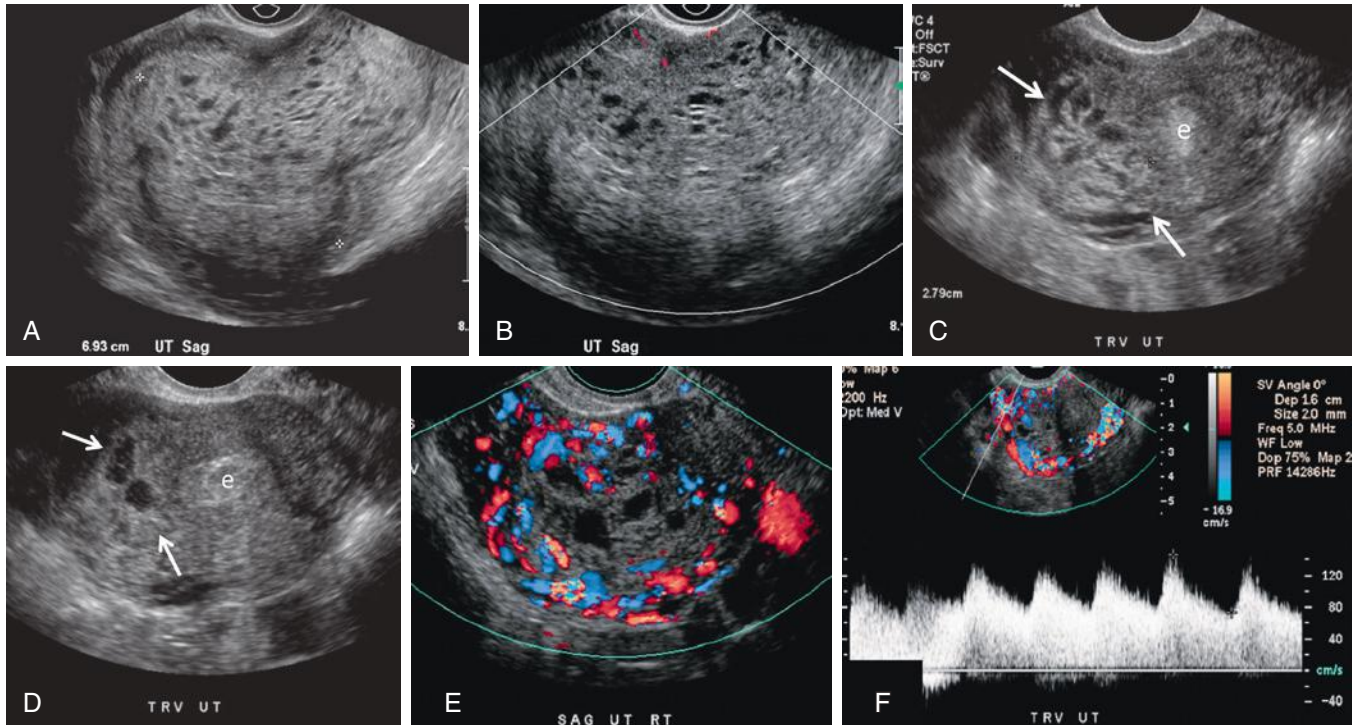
Persistent trophoblastic neoplasia (invasive mole). A, Sagittal gray-scale image of the uterus from a woman presenting with vaginal bleeding in the first trimester. The endometrial cavity is markedly distended by a lobular echogenic mass (*calipers*) measuring 6.93 cm containing numerous small cysts. Although the surrounding myometrium is thinned, there is no evidence of myometrial invasion. No gestational sac was identified. Findings are most consistent with a complete hydatidiform mole. B, Color Doppler imaging did not reveal increased vascularity within the molar tissue. Although increased vascularity is a common finding in molar pregnancies, the absence of significant Doppler-detected blood flow does not exclude the diagnosis. C and D, Six months following treatment, the patient returned with elevated serum human chorionic gonadotropin levels. Transverse gray-scale images reveal a complex myometrial mass (*arrows* and *calipers* in C; *arrows* in D) containing numerous cystic spaces and clearly separate from the endometrium (e). The endometrium (e) appeared normal. E, Sagittal color Doppler image reveals increased flow within the mass and in the surrounding myometrium. F, Spectral Doppler image demonstrates the classic “trophoblastic” waveform of gestational trophoblastic neoplasia characterized by increased peak systolic and end-diastolic velocity with a low resistive index (0.50). Findings are most consistent with recurrent, invasive gestational trophoblastic neoplasia.
